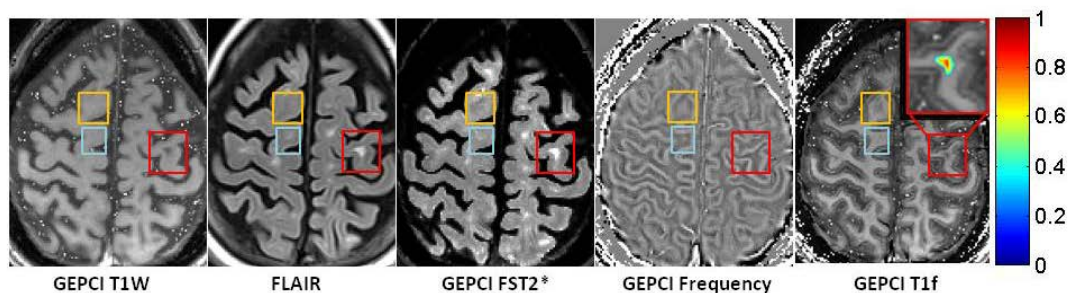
Example of data obtained from a subject with SPMS (female, age 49, EDSS 6.5). Note the prominent contrast between GM and WM on GEPCI T1f image as compared to other images. Rectangles outline abnormalities observed on FLAIR or Frequency (phase) maps. Orange rectangles denote an alteration seen in phase images (bright contrast) but not on T1W, FLAIR or GEPCI FST2*. This may represent a very mild lesion with damaged myelin, and is also seen on GEPCI T1f image as negative dark contrast. Blue rectangle outlines a small MS lesion that is barely seen on FLAIR and GEPCI FST2*, and is also visible on the phase image. Red rectangle outlines a severe MS lesion (very high TDS score) that is seen on T1W, FLAIR and GEPCI FST2* but does not have a footprint on the phase image. A magnified view of this lesion is shown in the inset (upper right of GEPCI T1f image) with overlaid GEPCI TDS score in color according to the color bar.
